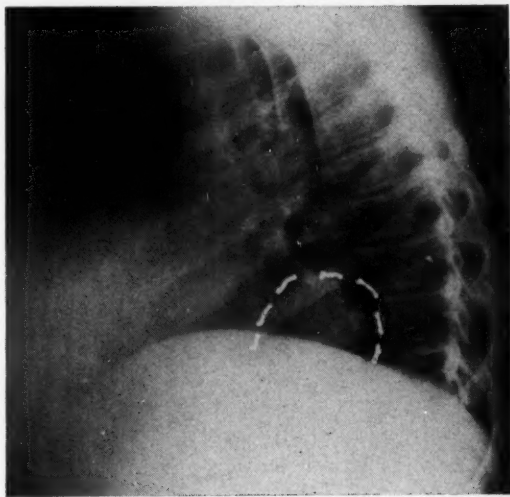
Chest x-ray showing "cannon-ball" metastasis in right base posteriorly.
